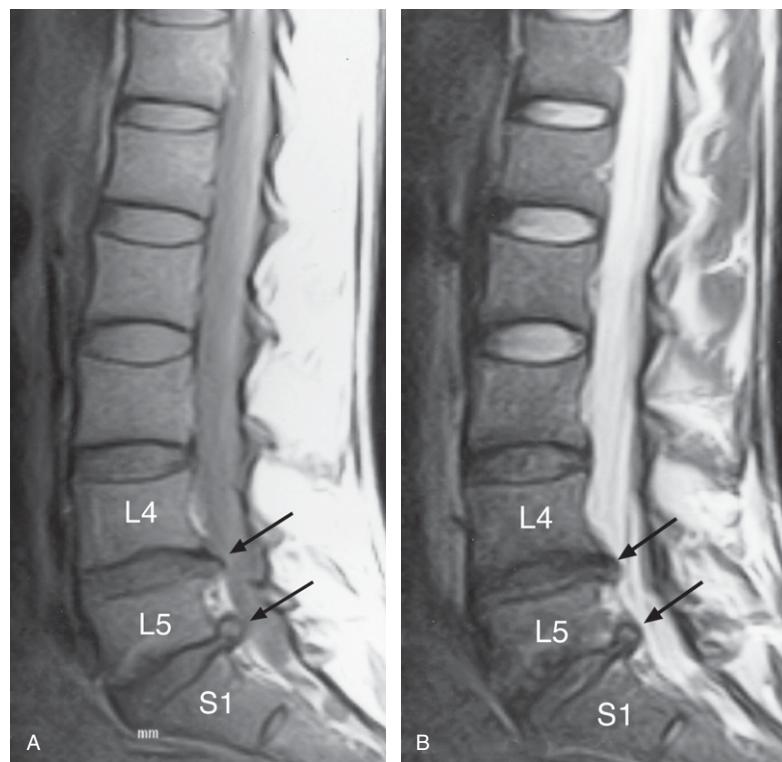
(A and B) Lumbar spine MRI parasagittal T1-weighted and T2-weighted images showing the disc protrusions at the L4–5 and especially the L5–S1 levels (black arrows). Note how the disc protrusions indent the anterior pain sensitive surface of the dural tube. The desiccation of the L3–4, L4–5 and L5–S1 intervertebral discs is seen in the T2-weighted view (B).
